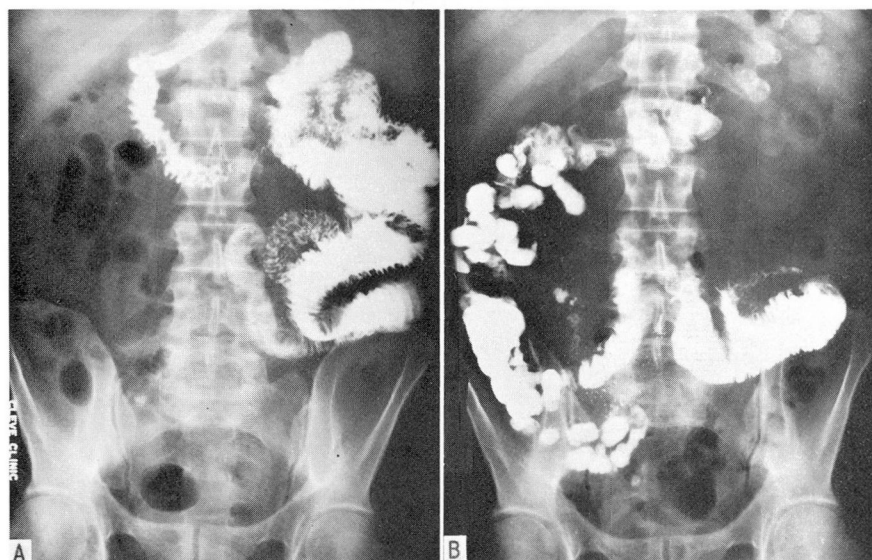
A, Roentgenogram made on October 9, 1961, of the small intestine after barium was swallowed. Evidence of a dilated loop of jejunum with multiple serrations suggesting ulcerations can be seen. B, Later the same day, the roentgenogram of the small intestine again shows evidence of the dilated jejunum and also a narrowed segment.
